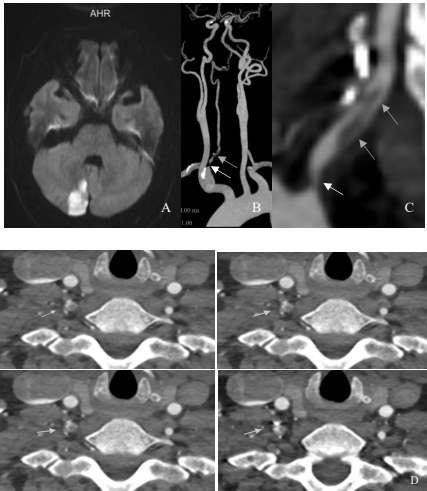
Cranial MRI-DWI on June 26, 2023 and Cervical CTA on June 30, 2023
